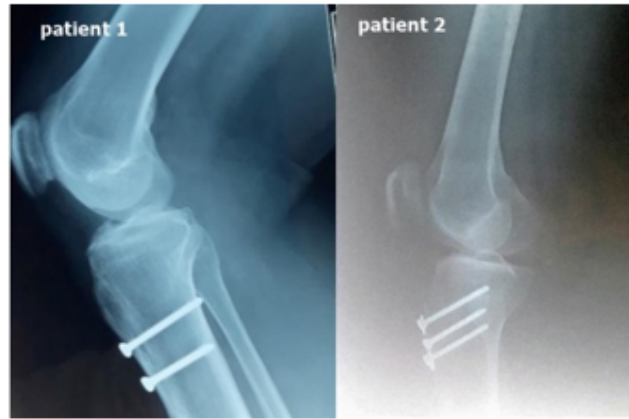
Post-operative X-rays showing tibial tubercle osteotomy fixed by cortical screws (profile incidences).
